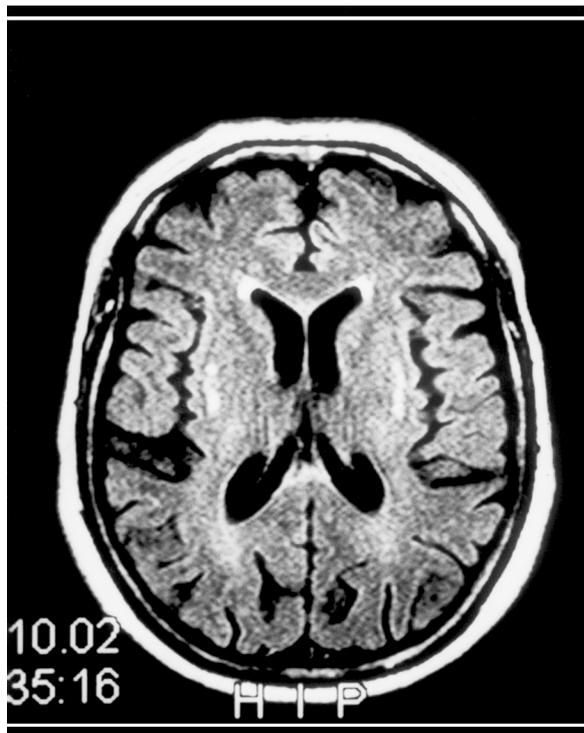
Case 1. Axial fluid attenuated-inversion recovery (FLAIR) MR imaging demonstrates bilateral symmetric increased signal intensity within the putamina.
